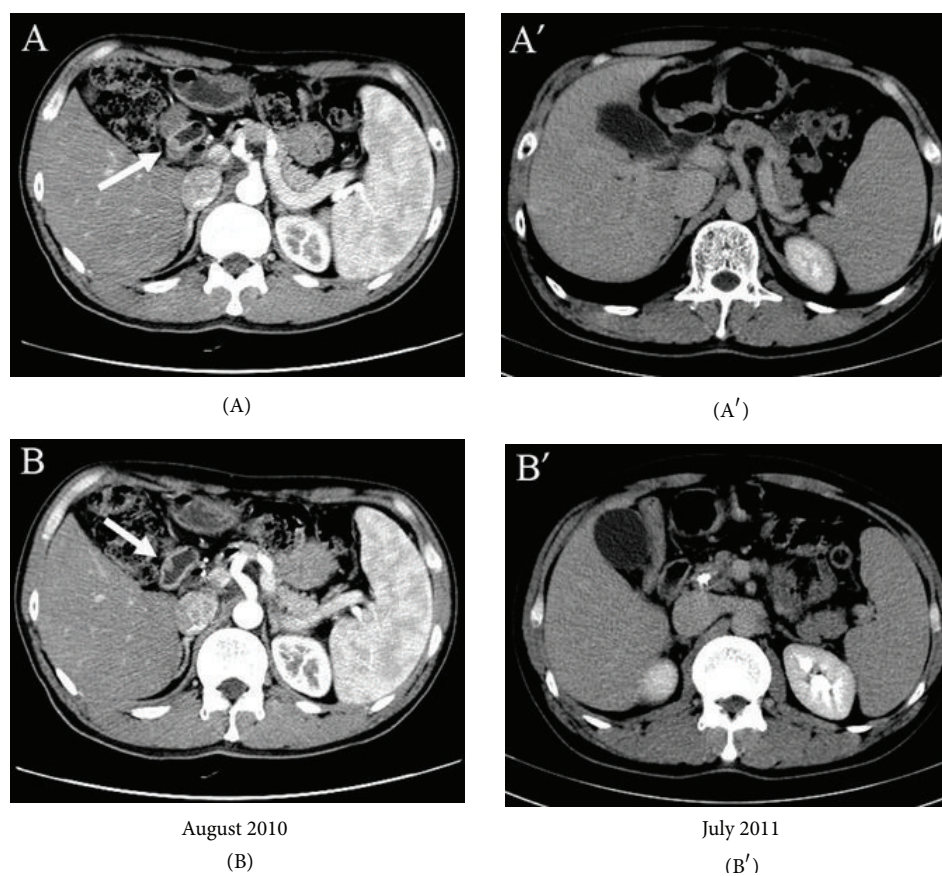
An abdominal CT scan in August 2010 revealed a mass in the ampulla of Vater lesion ((A) & (B)). After only aRVS treatment, a recent abdominal CT scan in July 2011 showed that no definite mass is seen in the region of the ampulla of Vater nor is there any definite evidence for metastatic mass ((A') and (B')).
